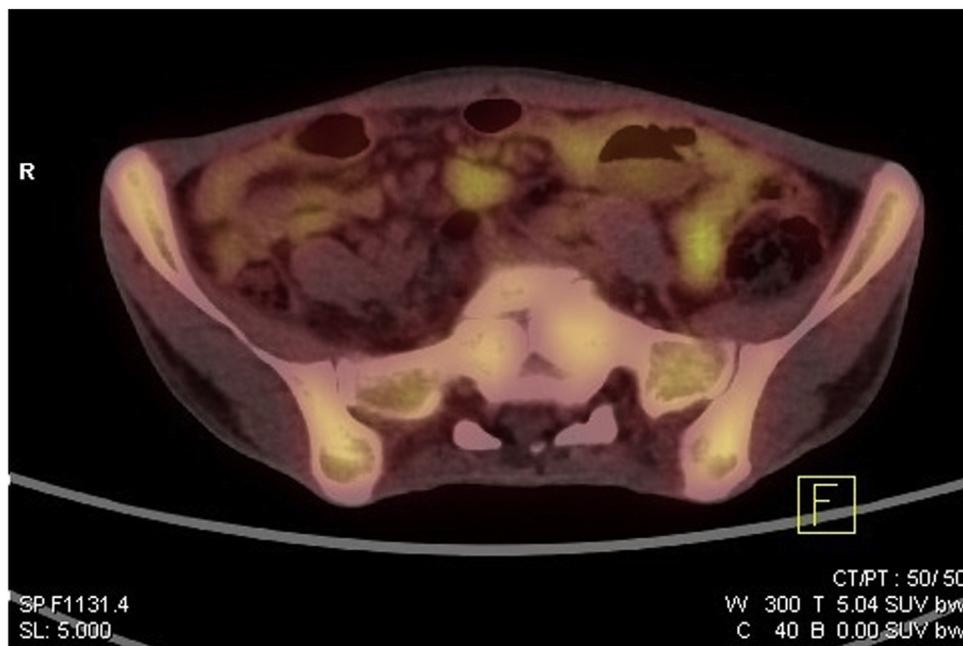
PET/CT revealed diffused FDG uptake in the small intestine.
